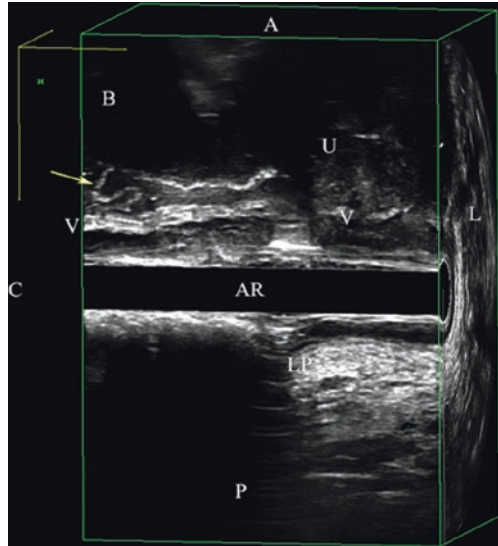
(a) 3D endovaginal ultrasound image (posterior compartment) in sagittal plane showing the posterior vaginal wall mesh (*white arrows*). Vagina (V), anorectum (AR), external anal sphincter (EAS), levator plate (LP); anterior (A), posterior (P), cephalad (C), left (L). (b) 3D endovaginal ultrasound image in midsagittal plane showing the posterior vaginal wall mesh prominence (*white arrows*). Vagina (V), anorectum (AR), levator plate (LP), anterior (A), posterior (P), cephalad (C), left (L), urethra (U). (c) 3D endoanal ultrasound image in midsagittal plane showing the posterior vaginal wall mesh in full length (*yellow arrows* point to the 58-mm cursors) past the apex of the vagina (V) (*yellow line*). Transducer (T) in the anorectum, anterior (A), bladder (B), cephalad (C), urethra (U). (© Shobeiri)
